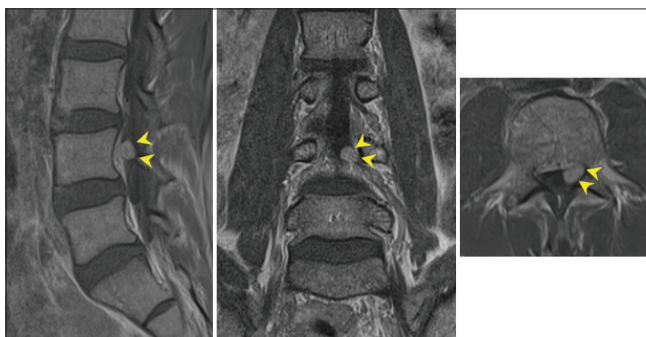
Preoperative contrast-enhanced magnetic resonance images showing a well-defined intradural extramedullary tumor (arrowheads) with homogeneous enhancement.
